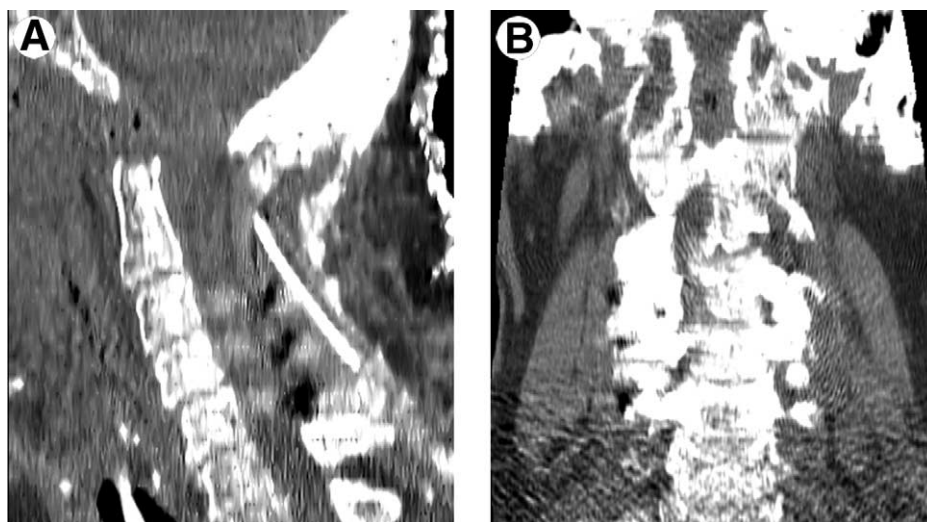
(A) Postoperative reformatted sagittal CT shows removal of the odontoid process and lower clivus. (B) Postoperative reformatted coronal CT confirms complete resection of the odontoid process inferior to the base of C2 and laterally to the lateral masses.
